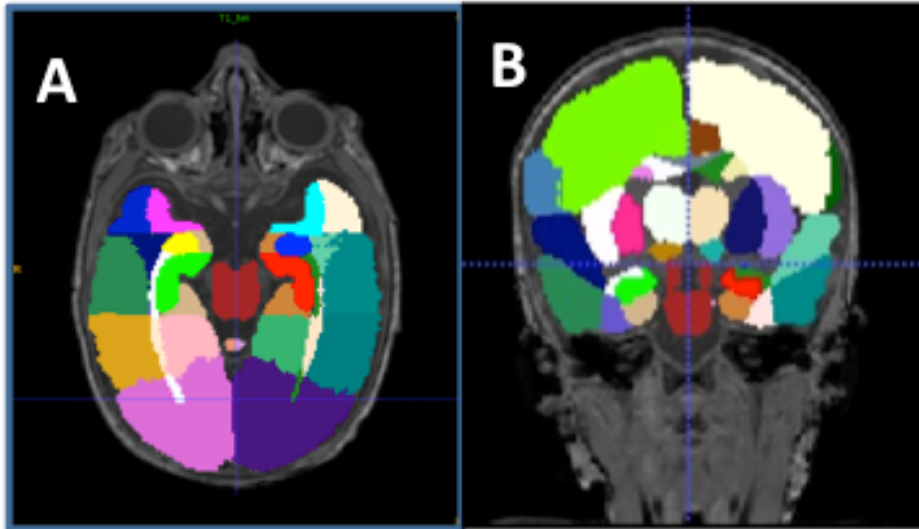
Brain MRI segmentation: A. axial and B. coronal view T1-weighted images.
